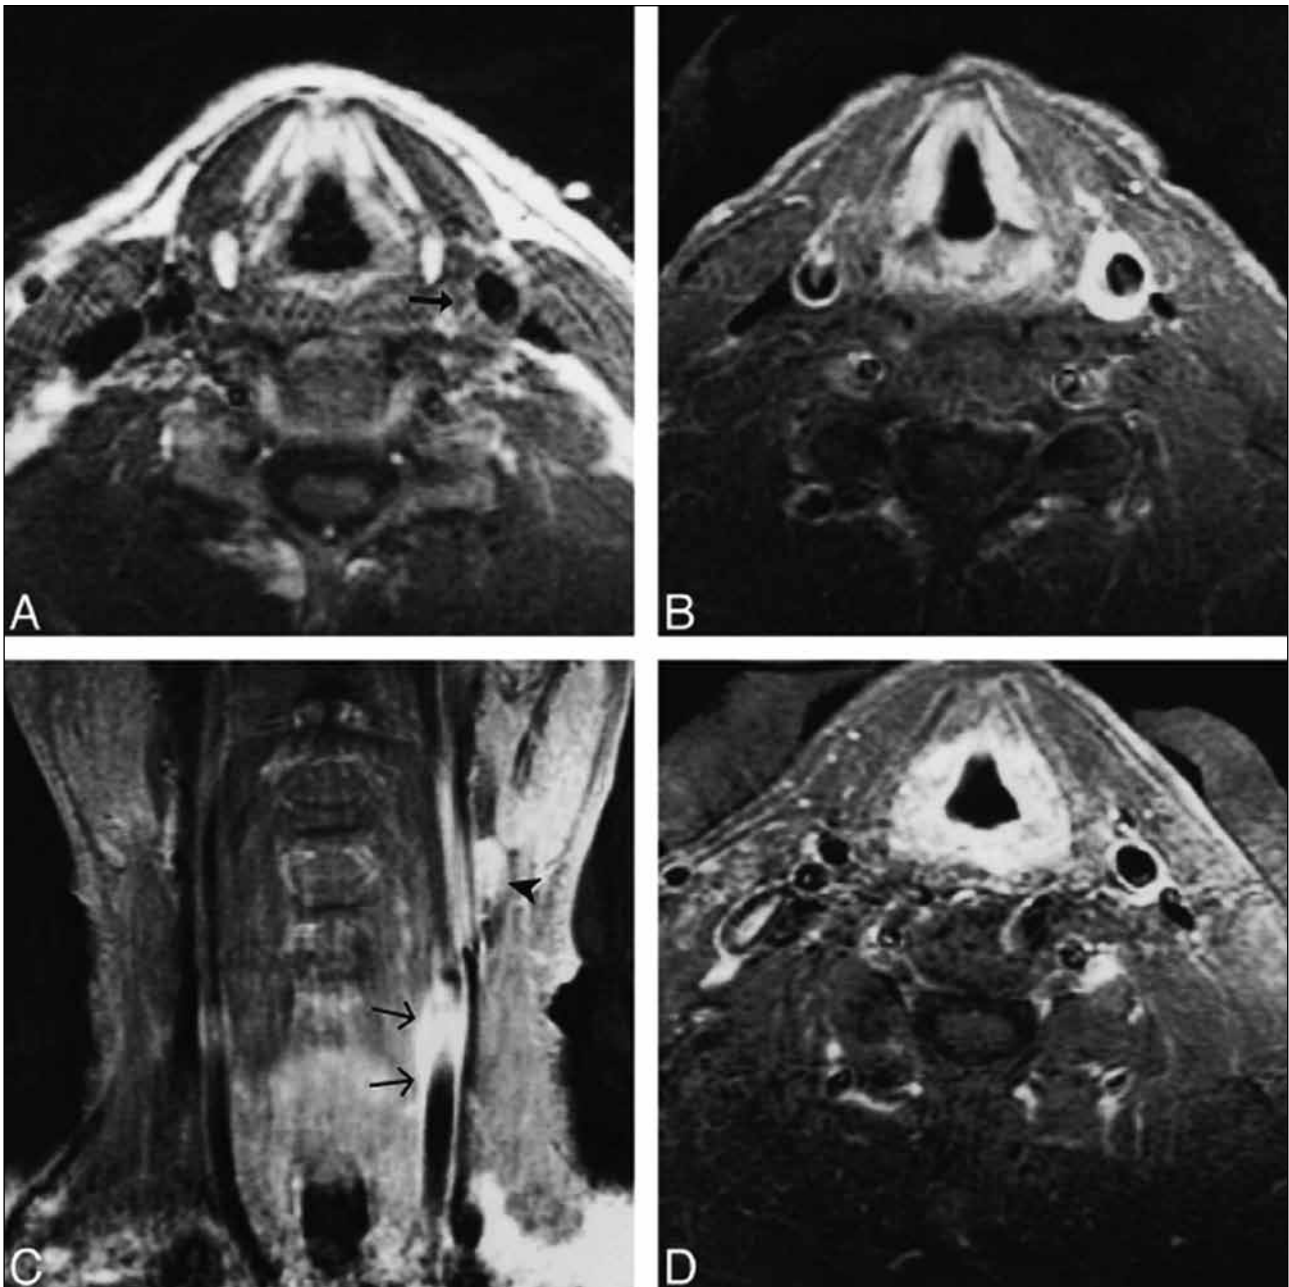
Axial contrast-enhanced T1-weighted MR images of a patient with left-sided carotidynia reproduced with permission of BS. Burtona, MJ. Symsa, GW. Petermanna and LPA. Burgessa: MR Imaging of Patients with Carotidynia. *AJNR Am J Neuroradiol.* 21(4):766-769. 2000 © by American Society of Neuroradiology.
